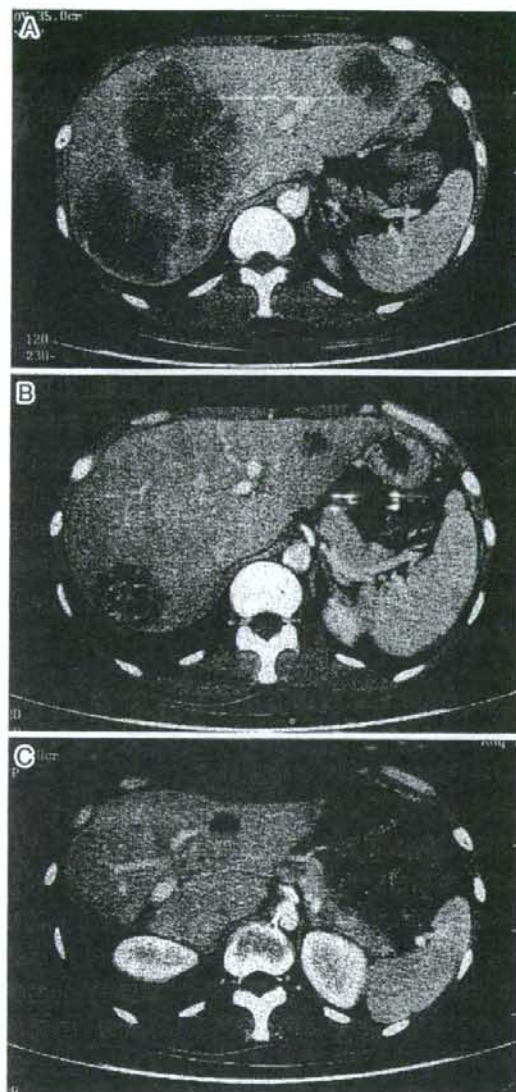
CT. A. Before chemotherapy. Multiple metastatic lesions were observed in both liver lobes. B. After FOLFOX therapy. A marked tumor reduction (56%) was observed. C. After FOLFIRI therapy. A 20% tumor reduction was noted.
